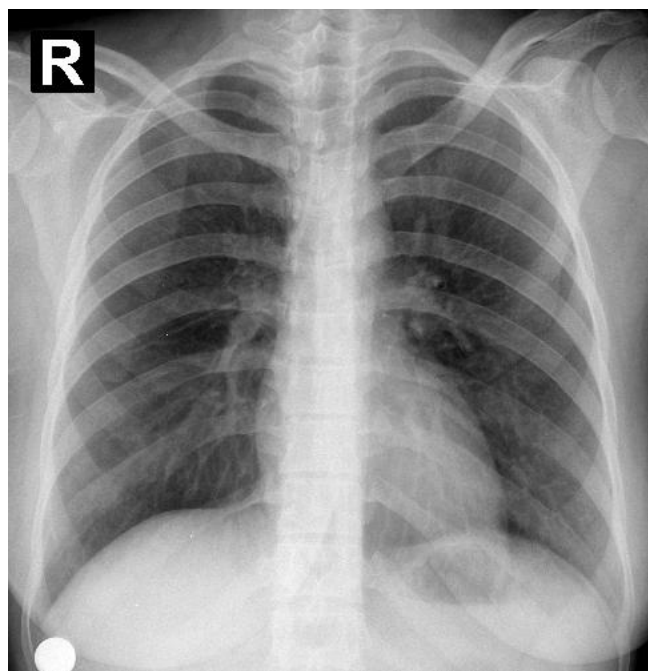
Chest radiograph on the third day showing clear lung fields.
